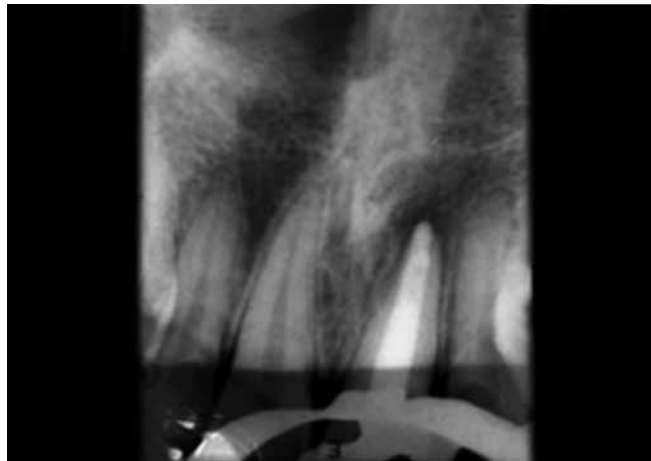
Postoperative radiograph after obturation (case 2)
